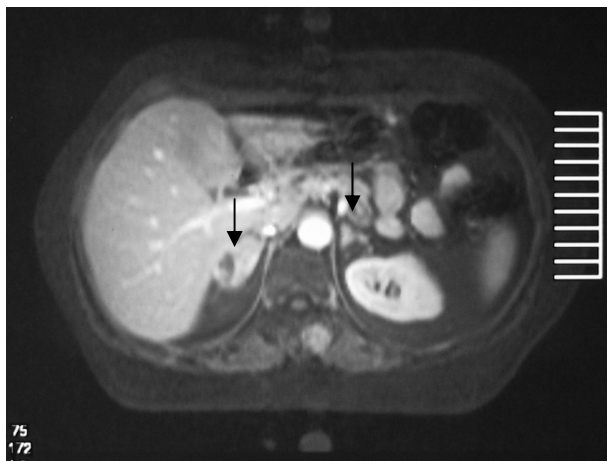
Post-contrast T1W fat-saturation MRI
